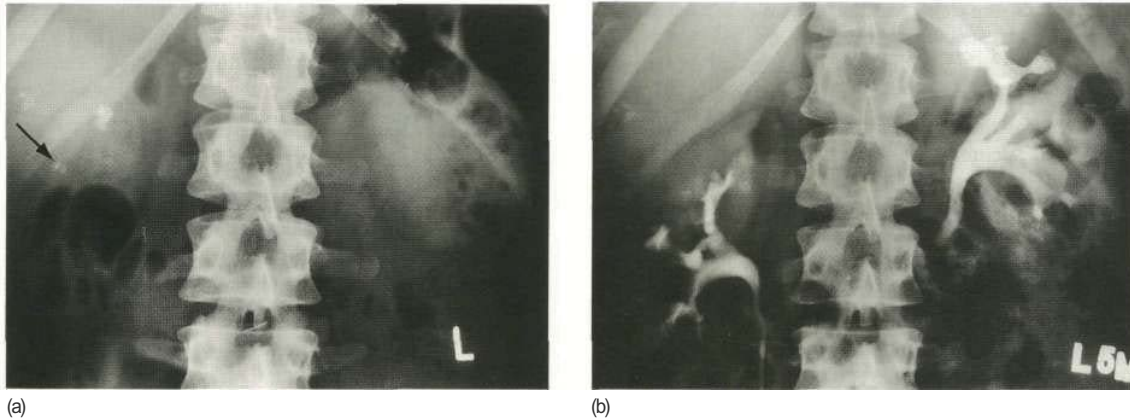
Medullary sponge kidney, (a) Plain film showing 'spotty' calcification in the renal areas (arrow), (b) After injection of contrast, the calcification is shown to be small calculi in the papillary zones.
